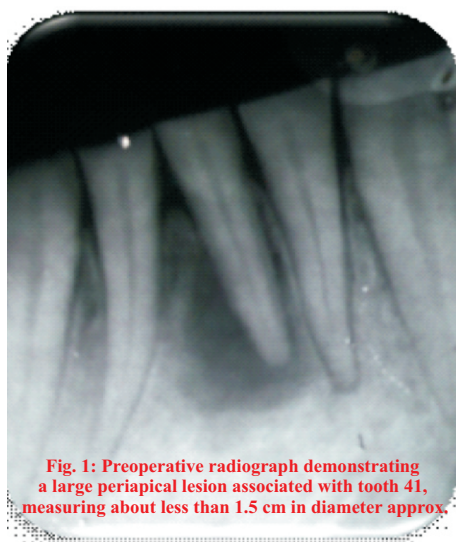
Preoperative radiograph demonstrating a large periapical lesion associated with tooth 41, measuring about less than 1.5 cm in diameter approx.
